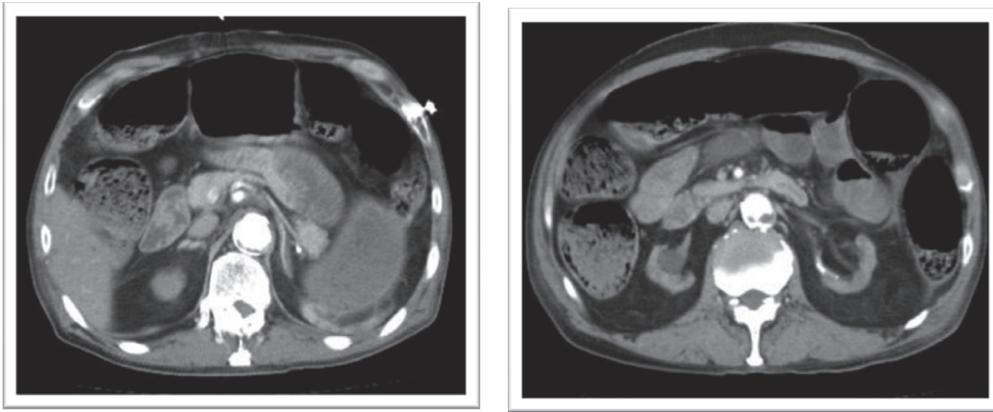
Abdominal CT of Case 1.
